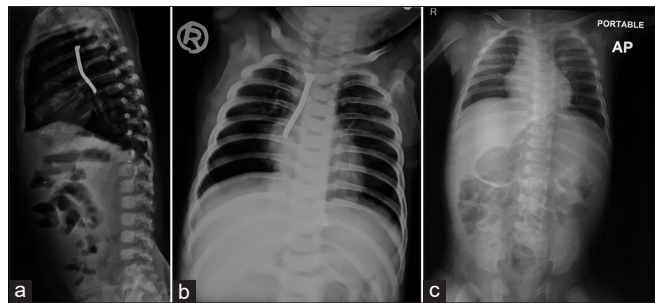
(a) X-ray chest AP View showing radiopaque foreign body in the right bronchus; (b) X-ray chest lateral view showing radiopaque foreign body; (c) X-ray chest AP view after spontaneous removal of foreign body
